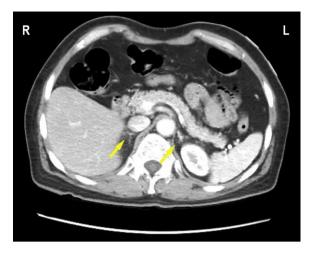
Abdominopelvic computed tomography without contrast upon initial presentation. Imaging of the patient's abdomen demonstrated grossly normal-appearing adrenal glands (yellow arrows).
